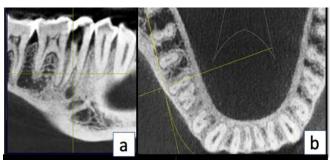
CBCT view of #45 (a)-sagittal view (b) -axial View
